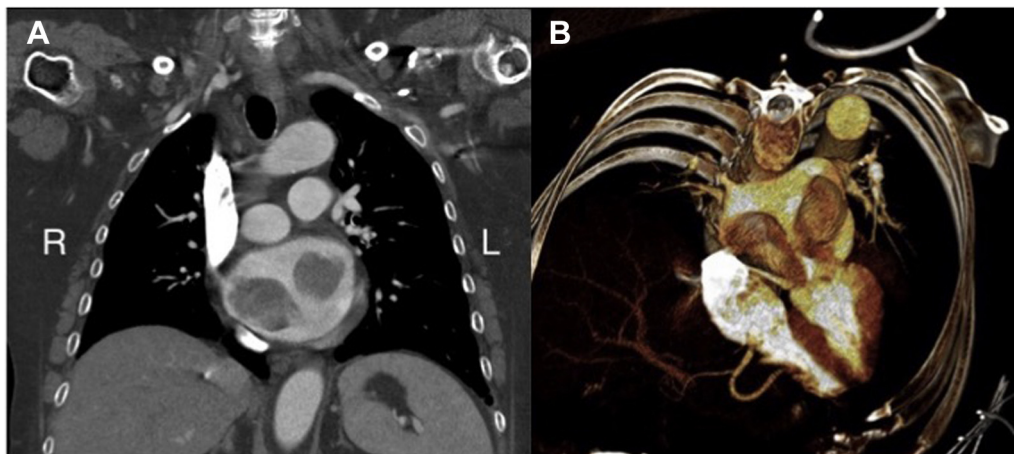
(A) Computed tomographic scan of the thorax showing a coronal view of the enlarged left atrium and two separate hypodense left atrial mass lesions. (B) Oblique three-dimensional reconstruction of computed tomographic transverse view of the thorax demonstrating the same pathology.
